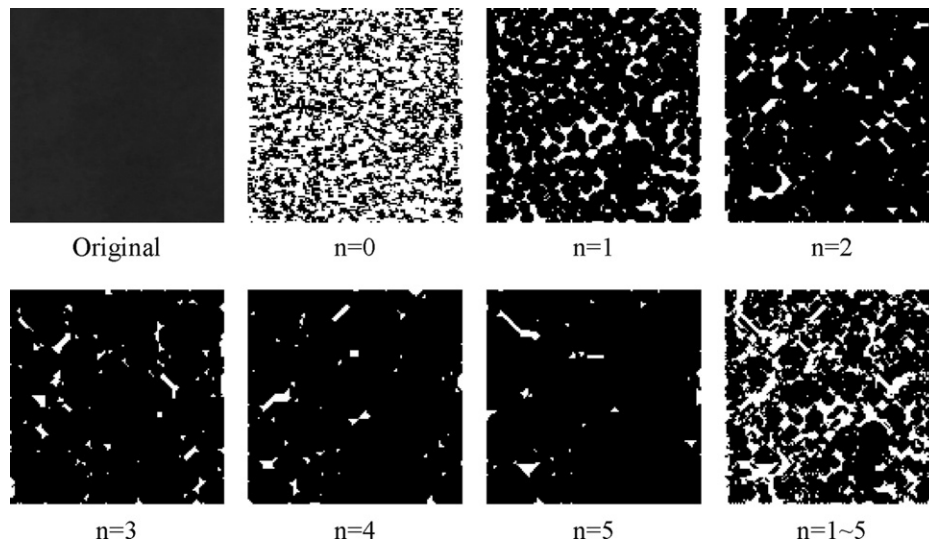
Series of morphologically processed subset periapical images including the original image, the processed image with different iterations ( $n = 0, 1 \dots 5$ ), and the sumset image ( $n = 1-5$ ).
